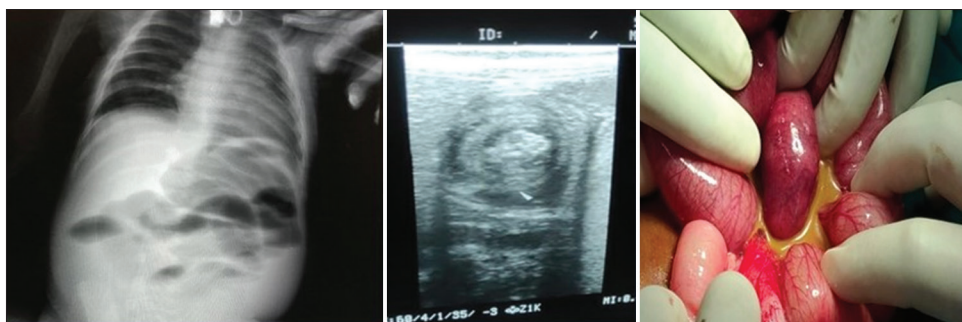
X-ray, ultrasound, and intraoperative findings of case 2
